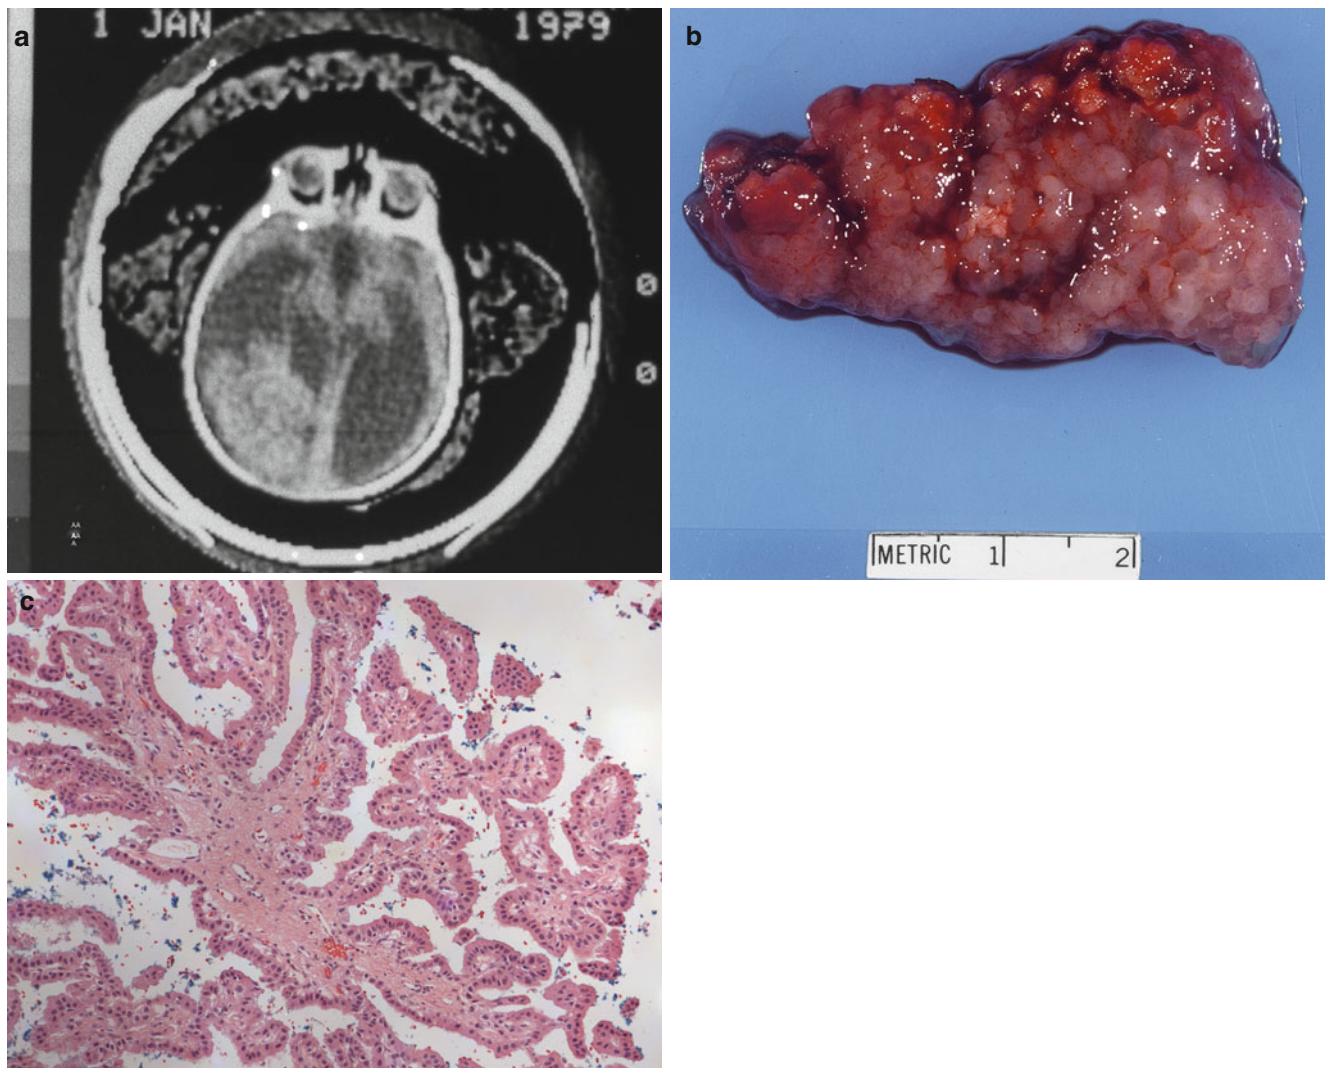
Congenital choroid plexus papilloma. Rapidly progressive hydrocephalus, a bulging fontanelle, and vomiting were the presenting signs in this 1-month-old female. (a) CT scan reveals a large, enhancing mass partially filling the left lateral ventricle and severe hydrocephalus. (b) Two cauliflower-like masses, 5.5×2.7 cm and 4.7×3.5 cm, were
